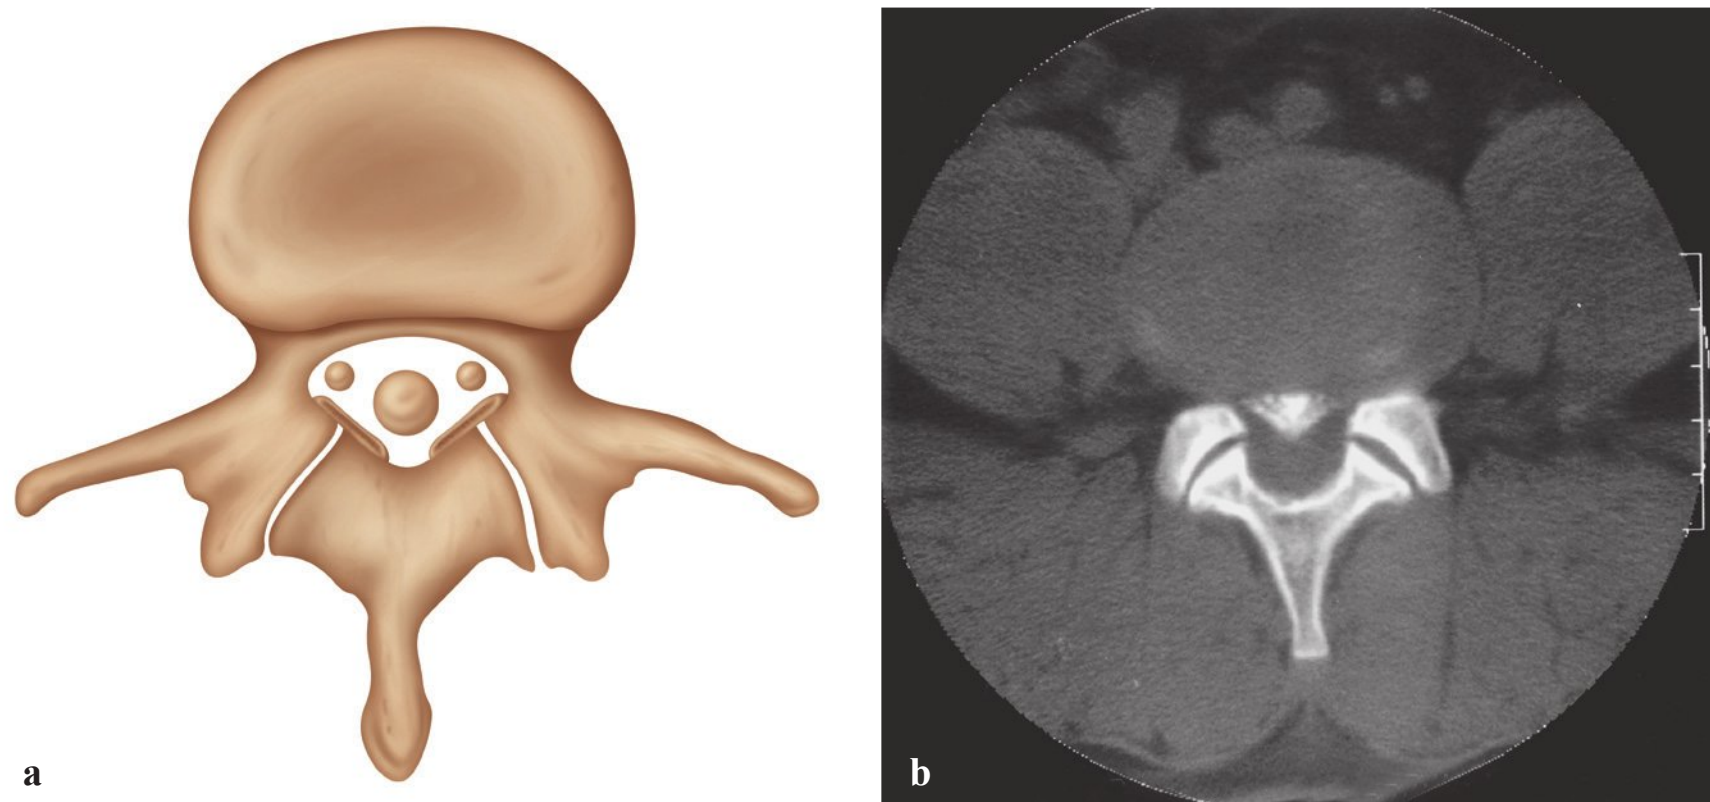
(a) Cross-sectional view of the normal anatomy of the neural structures within the spinal canal. (b) Computed tomographic myelography demonstrating central stenosis with significant ligamentum flavum hypertrophy.
